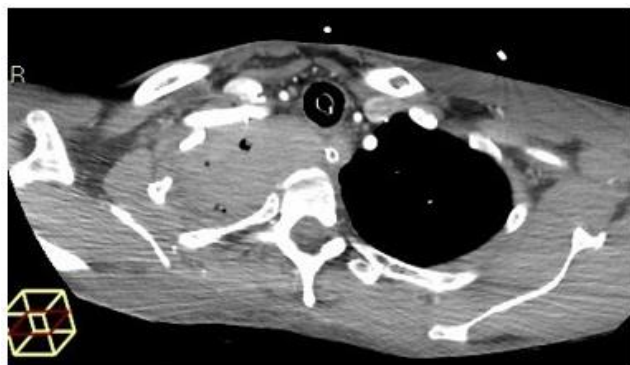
Post-operative control CT showing the stent well positioned and no signs of bleeding in progress.
